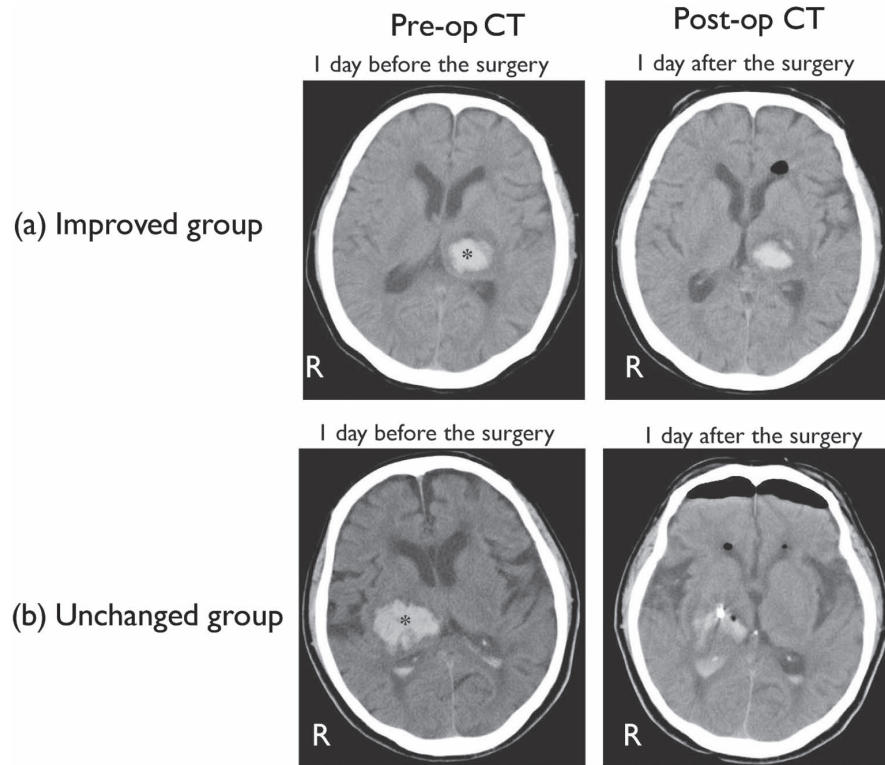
Pre- and Post-operative CT scans.
